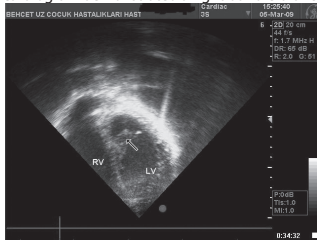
Echocardiogram showing the large muscular false tendon
